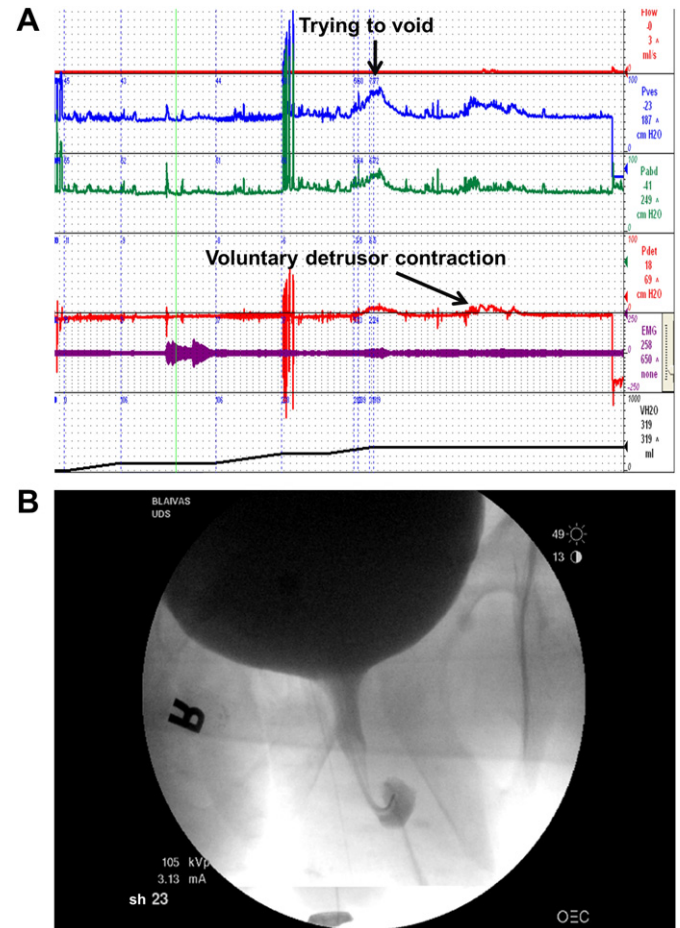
Impaired detrusor contractility. This 50-year-old man had a 2-year history of overactive bladder (OAB) symptoms. The exam was unremarkable except for an absence of the bulbocavernosus reflex. A prior urodynamic study 1 year previously had shown detrusor overactivity, and he was started on anticholinergics without success. He developed urinary retention that was treated with intermittent catheterization, and this urodynamic study was done about 3 months later. A. Urodynamic tracing. The bladder capacity was 319 mL. He initially tried to void by straining but was unsuccessful. He then voided with a very weak, poorly sustained detrusor contraction. $P_{det}@Q_{max} = 10$ cmH₂O; $Q_{max} = 1$ mL/s. The detrusor contraction only lasted about 20 s. B. X-ray exposed at Qmax showing a wide-open prostatic urethra with some narrowing in the membranous region. Empiric transurethral resection of the prostate on a patient like this is very unlikely to be effective because of the short-lived, weak detrusor contraction and the open urethra on the voiding cystourethrogram as seen in 4B. He remains on intermittent self-catheterization.
